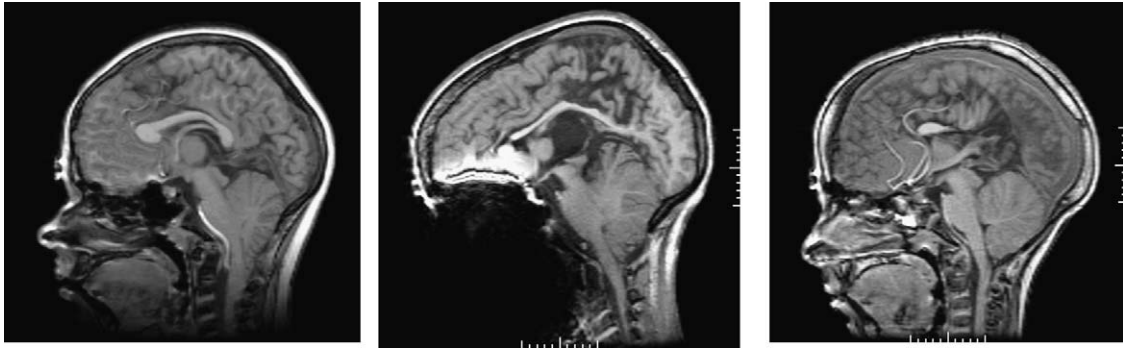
Corpus callosum in mid-sagittal structural MRI slices of children with SBM. Intact corpus callosum (left), corpus callosum hypoplasia (middle), and corpus callosum agenesis (right).
